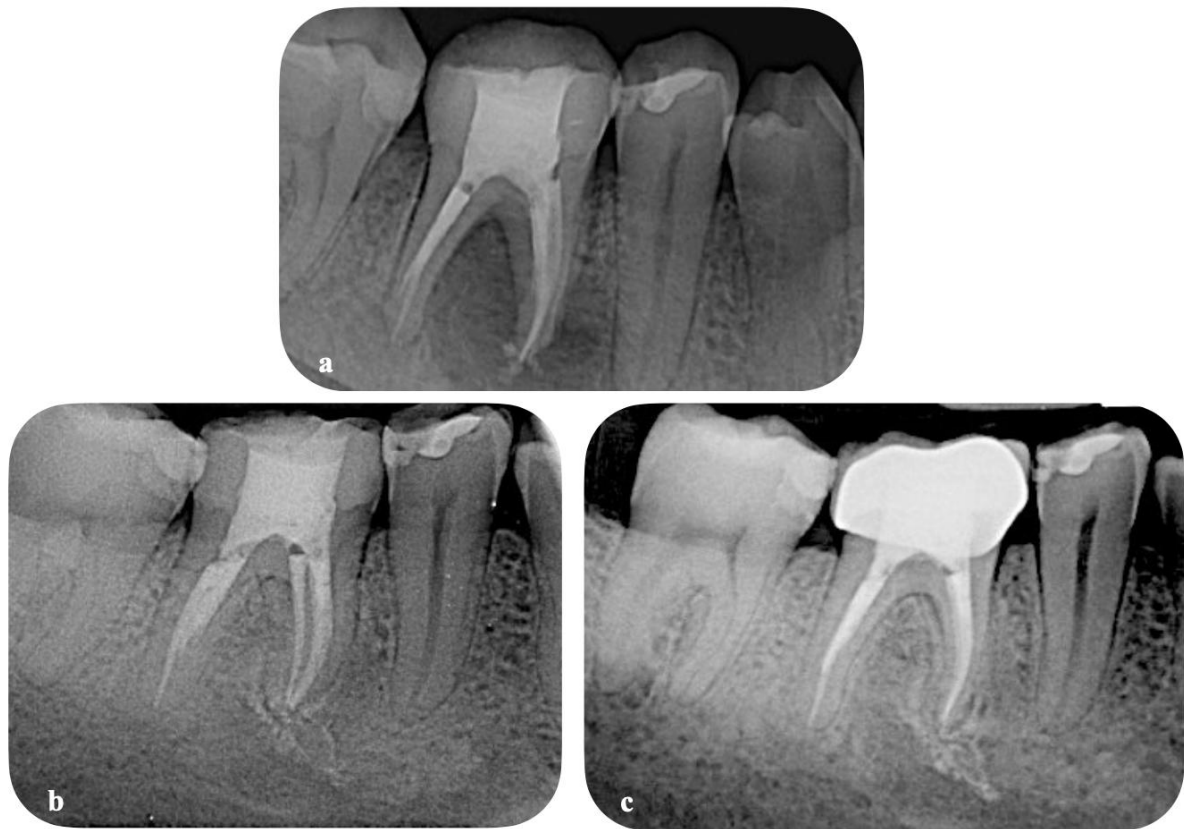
Radiographic monitoring of periapical healing of tooth #46: a/ postoperative radiograph after the obturation- PAI score 5; b/ radiograph - 6 months follow up – PAI score 1; c/ 1 year follow up with definitive crown.
